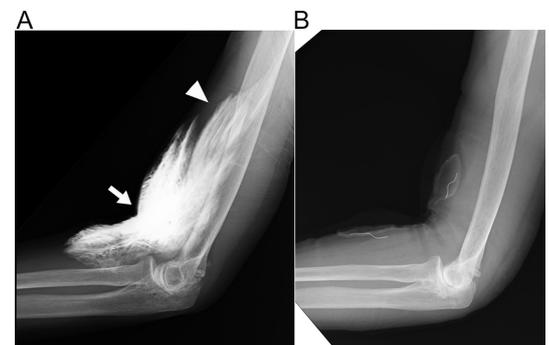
Simple radiograph of the right arm. (A) Contrast medium (CM) in superficial soft tissues of the antecubital fossa (arrow) and subfascial extravasation of the biceps muscle compartment (arrowhead) were detected. (B) CM was undetectable 1 day after drainage.
